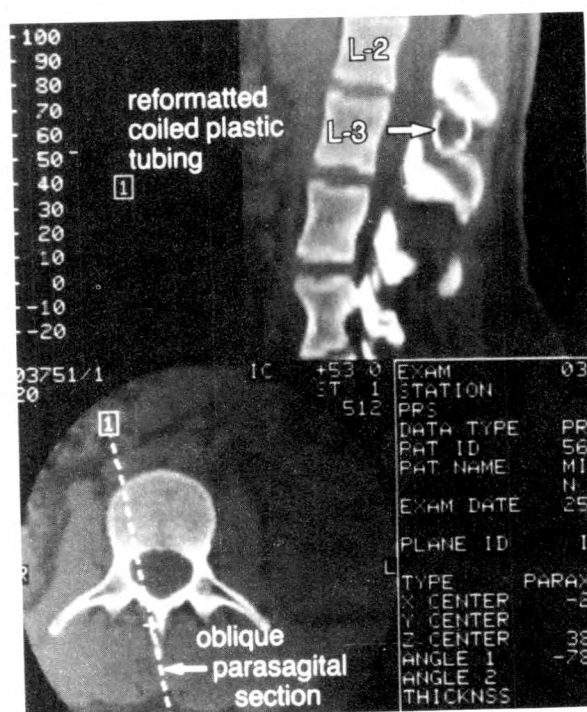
Computed tomography reformatting of the plastic tubing confirming its precise location lateral to the interspinous ligament of L2-3.
